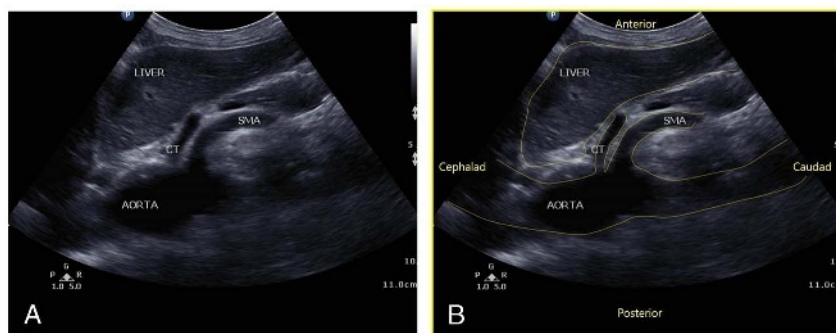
Longitudinal view of the aorta, showing the aorta, celiac trunk, and the superior mesenteric artery (SMA) and the celiac trunk (CT).
